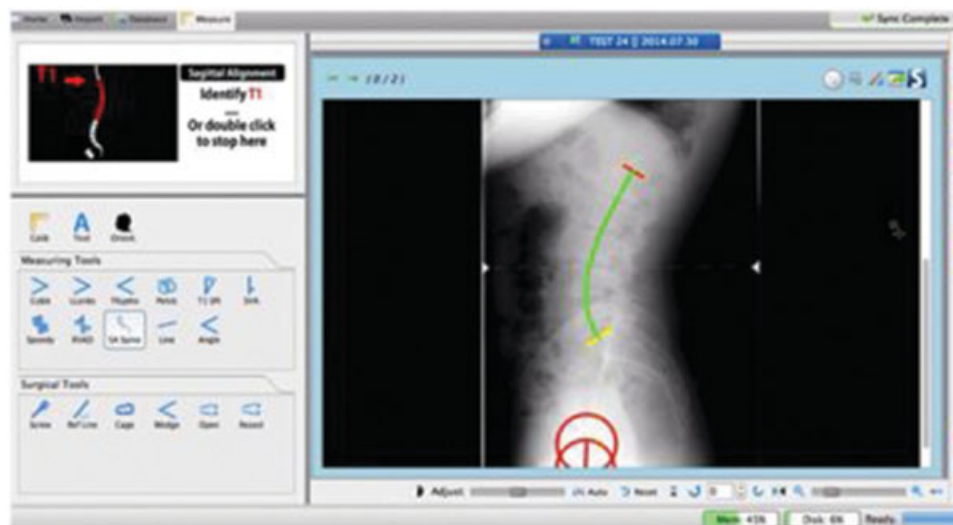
Example of measurements using Surgimap software: Lateral orthostatic lumbosacral X-ray including femoral heads.
